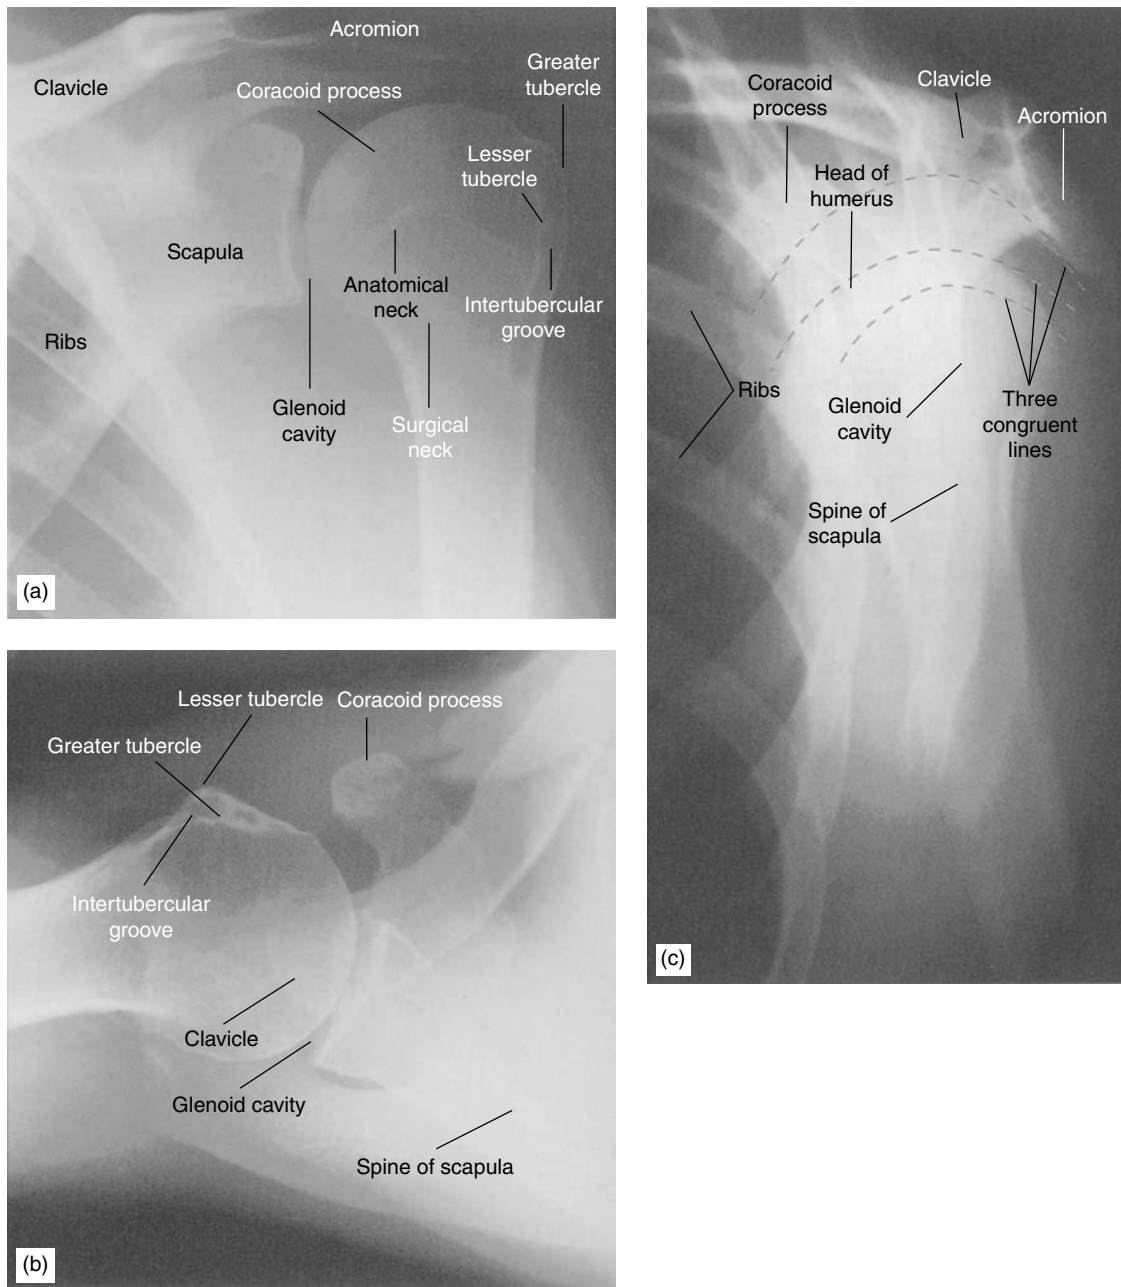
(a) Anteroposterior, (b) axillary, and (c) lateral radiographic projections of the shoulder. Reproduced from Butler P, Mitchell AWM, Ellis H, *Applied Radiological Anatomy*, Cambridge University Press, Cambridge, 1997.
